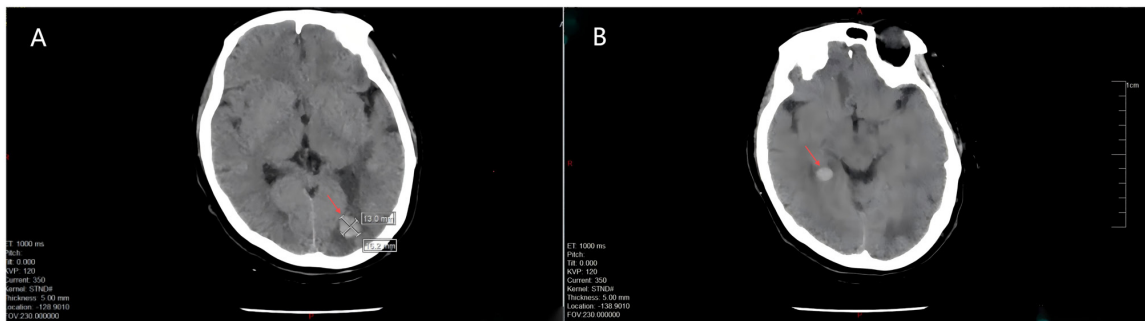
Multiple metastatic intracranial tumors shown on cranial CT (arrows indicate the brain metastasis focus). (A) Level of the body of the lateral ventricle. (B) Level of the midbrain.
